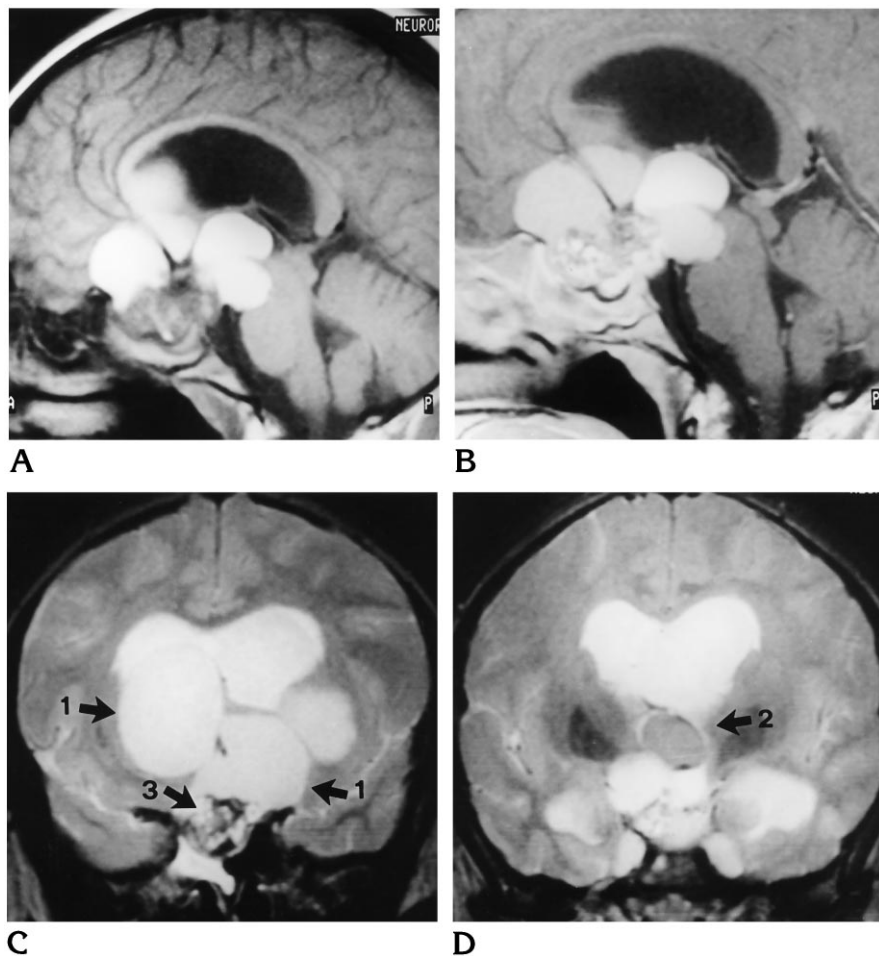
Noncontrast (A) and contrast-enhanced (B) sagittal T1-weighted MR images show a lobulated adamantinous tumor with multiple hyperintense cysts and a solid inhomogeneous mainly hypointense area with punctate hyperintense foci on the noncontrast image. The hyperintense cysts do not enhance after injection of contrast material; the solid tumor part enhances inhomogeneously. Encasement of the pericallosal artery and the basilar artery is present.
